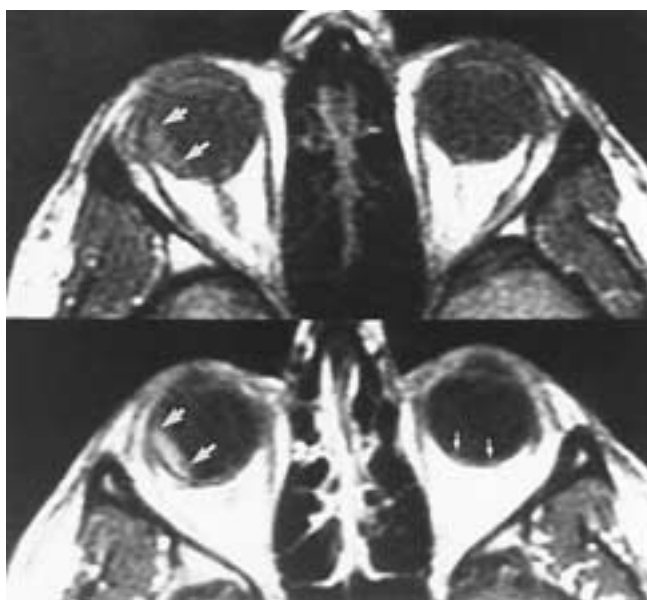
Uveal metastasis. Axial precontrast (top) and postcontrast (bottom) T1-weighted MR images show bilateral choroidal metastases (arrows).
